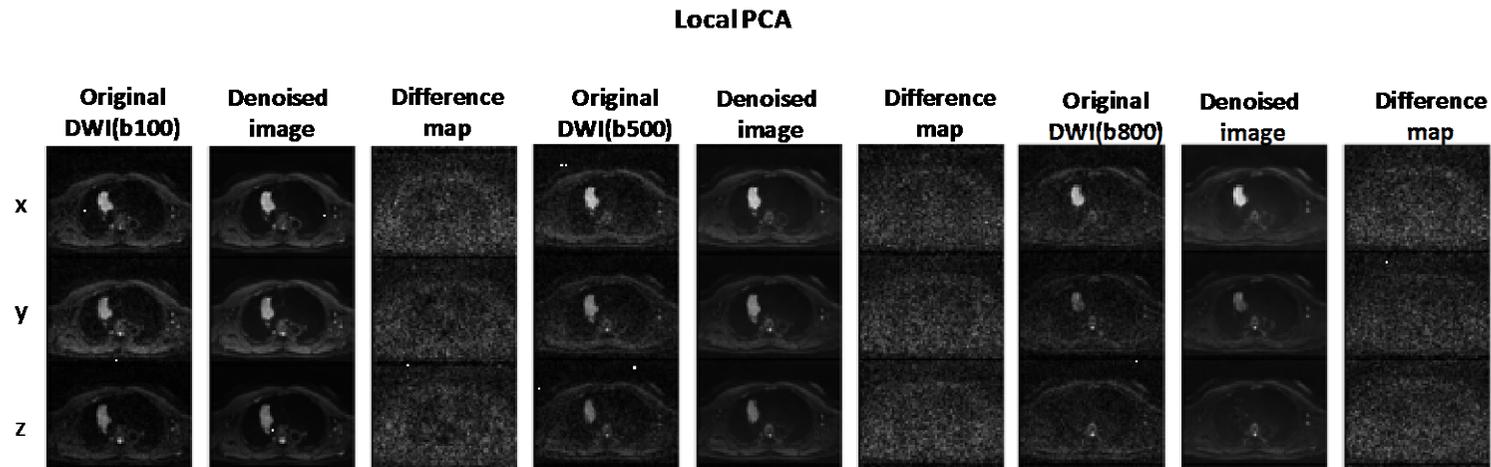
The performance of local PCA on DWI images of a 77-year-old male MPM patient acquired at different b-values.
